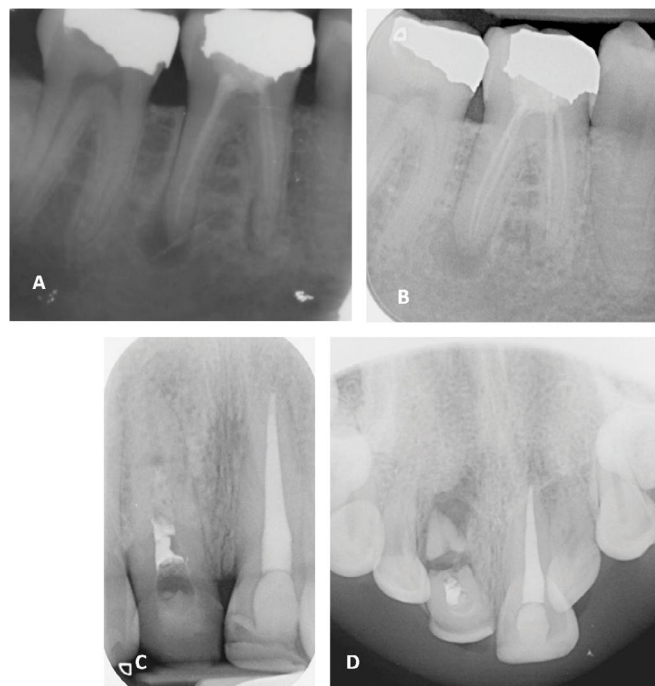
Image A and B show an example of horizontal parallax shift during assessment of a patient referred with pain from previously root canal treated tooth 46. The x-ray tube head is more mesially positioned in image B which reveals there are four previously obturated canals, not the three suggested in image A. Image C is of tooth 11 referred by the patient's GDP stating a perforation and internal root resorption in tooth 11 was identified when root canal treatment was commenced. The patient relates a history of trauma and describes a lateral luxation of tooth 11. A maxillary occlusal radiograph (Image D) sheds light on a different diagnosis: an unhealed mid-third horizontal root fracture and periradicular changes are seen. This is an example of a vertical parallax shift which shows the horizontal root fracture more clearly than the periapical image (C), clarifying the diagnosis and steering treatment planning
